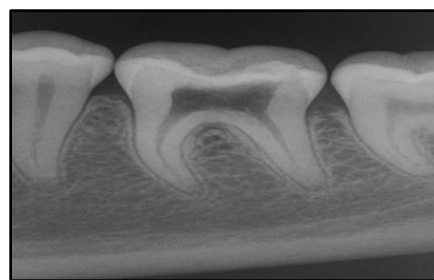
Radiographic assessment 2
